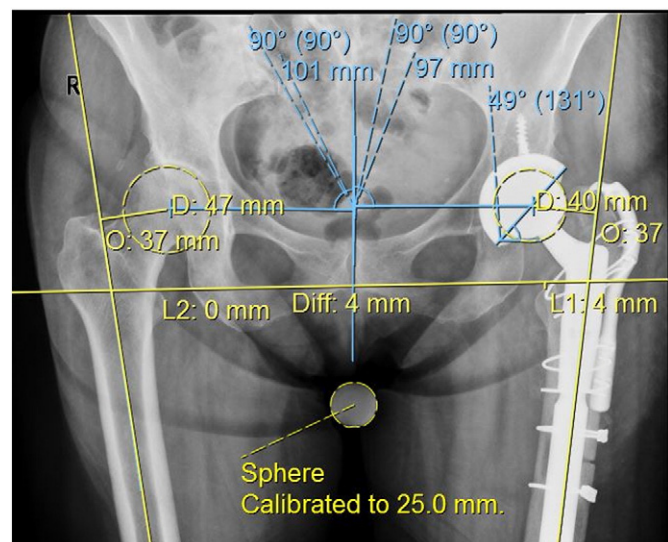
Example of radiographic measurements.
